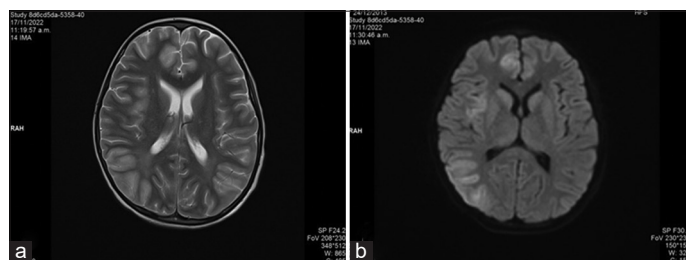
(a and b) Brain magnetic resonance imaging right frontoparietal cortico-subcortical hyperintensity in T2 and fluid-attenuated inversion recovery
